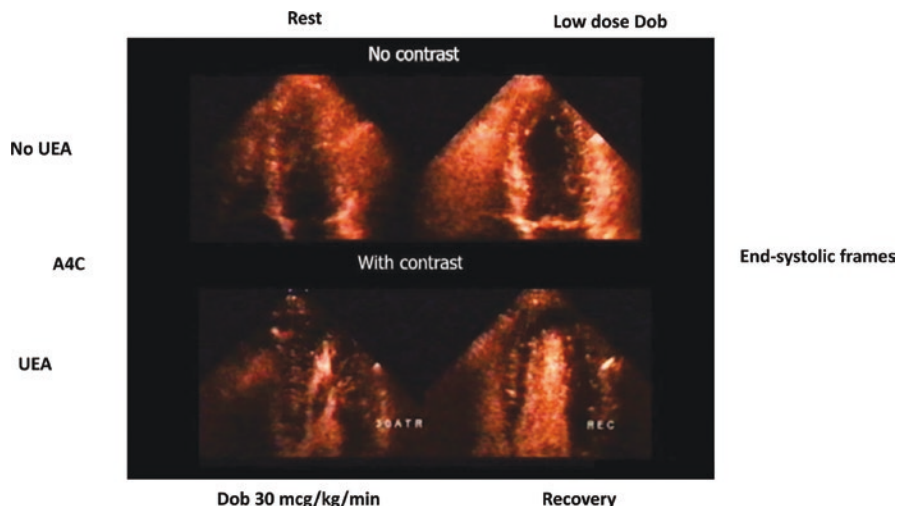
Apical four-chamber at rest (left upper panel) and after low dose (right upper panel) without contrast, and at peak dose (left lower panel) and the recovery phase (right lower panel) following ultrasound-enhancing agents, with the improvement of image quality and endocardial border delineation in a negative test without wall motion abnormalities. See the corresponding Video 18.6. (By courtesy of Dr. Ana Cristina Camarozano, Curitiba, Brazil. The video is available under the chapter’s “Supplementary Material” on Springer Link)
